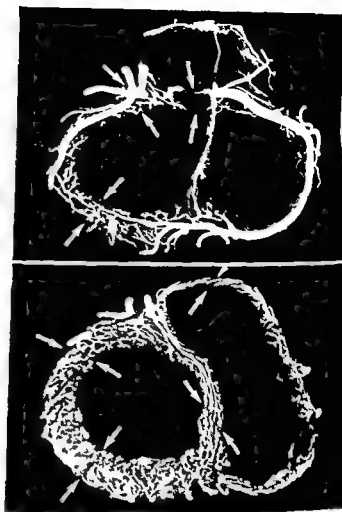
In these radiographs of the basal slice (upper figure) and of a slice taken from the middle (lower figure) of the same heart (autopsy number 5590/72) the boundaries between the coronary vascular areas are indicated by arrows. There is a sharp line of demarcation between the areas. Of course one can only determine the vascular areas by comparison with the adjoining slices.
